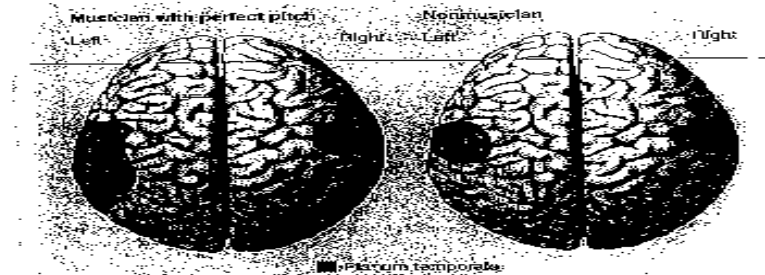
The anatomical asymmetry detected in the planum temporale of musicians by magnetic resonance imaging. In most people, the planum temporale is larger in the left hemisphere than in the right; this difference was found to be greater in musicians with perfect pitch than in either musicians without perfect pitch or control subjects. (Adapted from Schlaug et al., 1995.)
